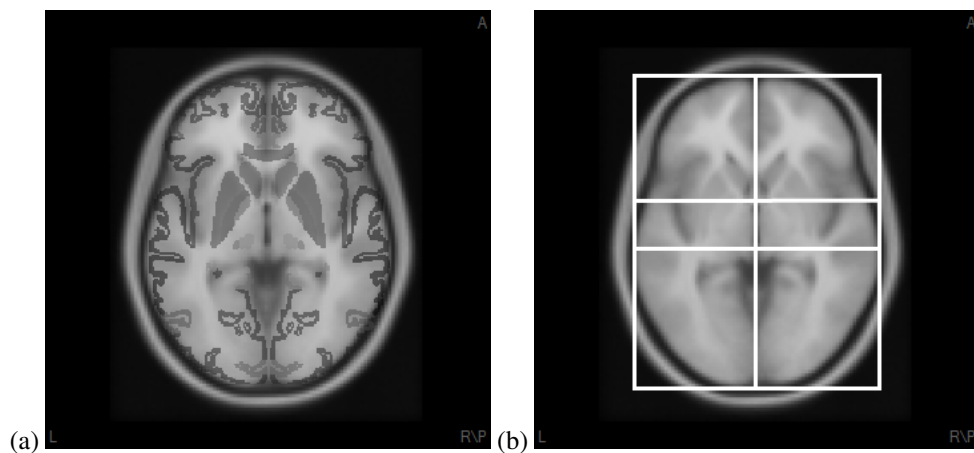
(a) an axial slice of the ICBM-152 averaged T1-weighted MRI dataset with overlaid Talairach atlas information where shades of gray encode anatomical features. (b) ICBM-152 slice with overlaid Talairach coordinate system bounding box through the locations of AC and PC.
